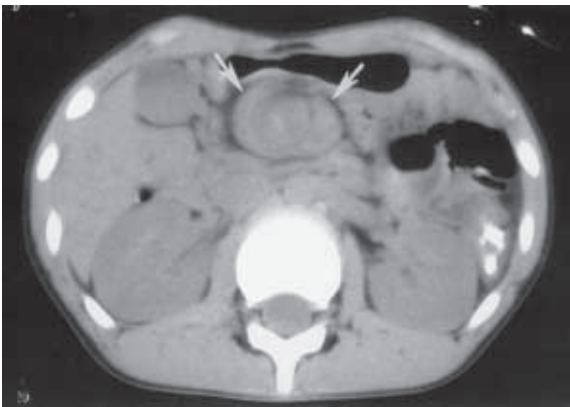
Malrotation with volvulus. Non-contrast CT shows a mass (arrows) in the mid-abdomen with whorled appearance due to volvulus.
